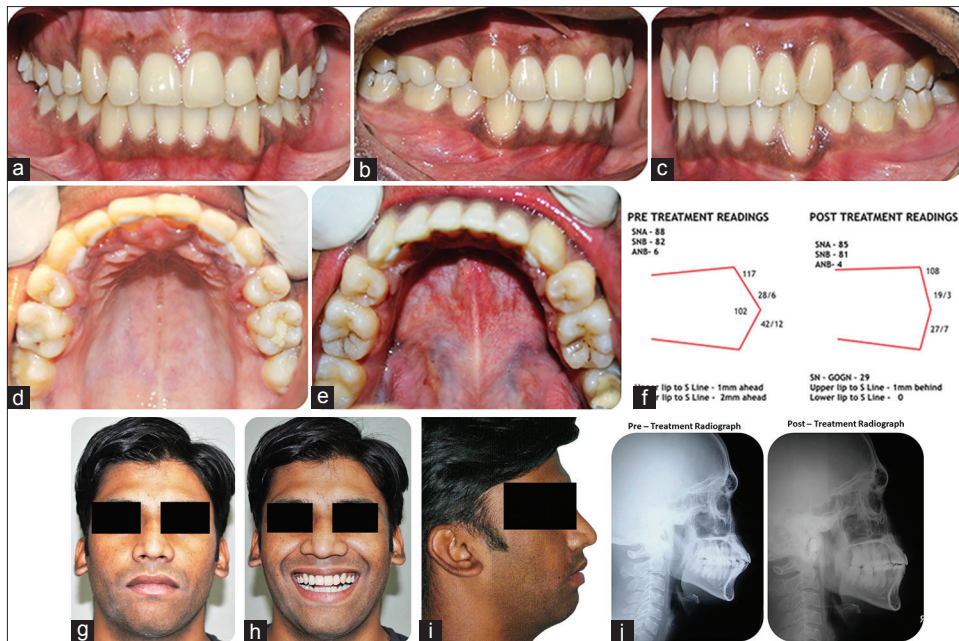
(a-j) Post treatment Extraoral, Intraoral Photographs and Radiograph
